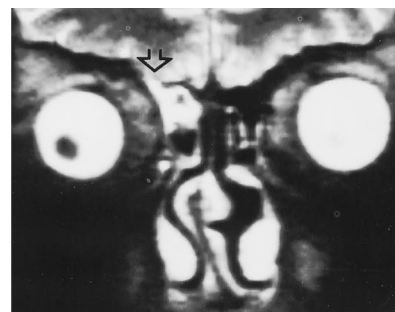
Fast spin-echo T2-weighted coronal MR image through the frontal sinus shows a hyperintense CSF column extending extracranially through the defect at the roof of the right frontal sinus (arrow).
